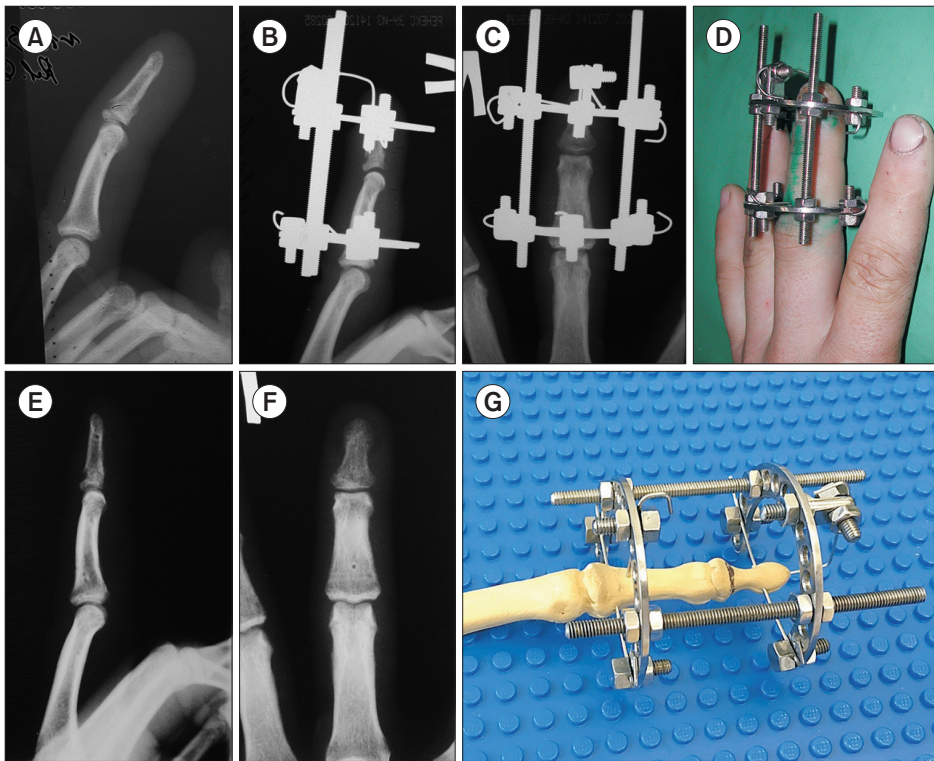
(A) X-ray 5 days after trauma; (B–D) X-ray and photo of the hand 4 weeks after surgery; (E, F) X-ray 6 weeks after surgery; (G) the proposed method of assembling the apparatus on a bone model.
